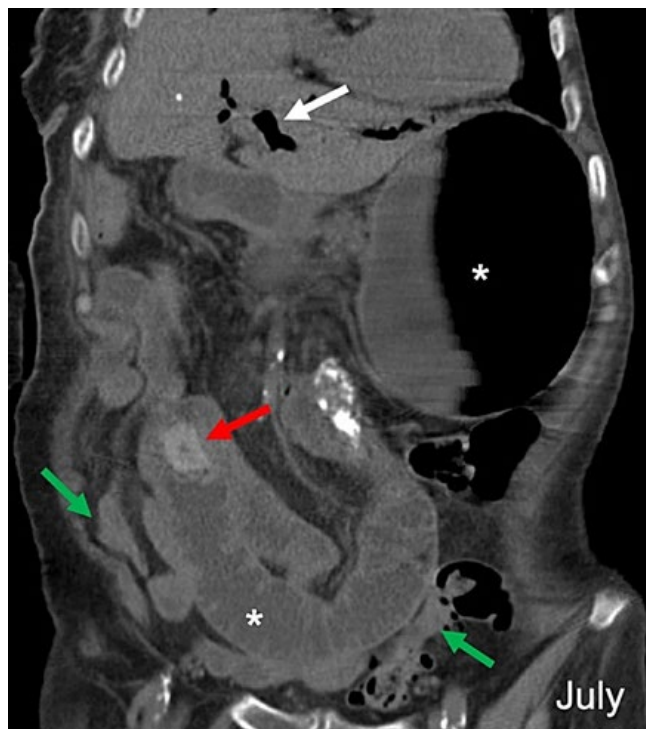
Contrast CT of the abdomen and pelvis in the coronal plane at the time of admission demonstrating an impacted endoluminal calculus with 2 cm in the small bowel (red arrow). Notice the upstream dilatation of the small bowel (*) and stomach (*) and the normal caliber of the colon (green arrows), meaning a mechanical obstruction is present. The biliary tree is also dilated and with pneumobilia (white arrow), meaning a probable fistula with the small bowel was present, in this case a choledocoduodenal.
